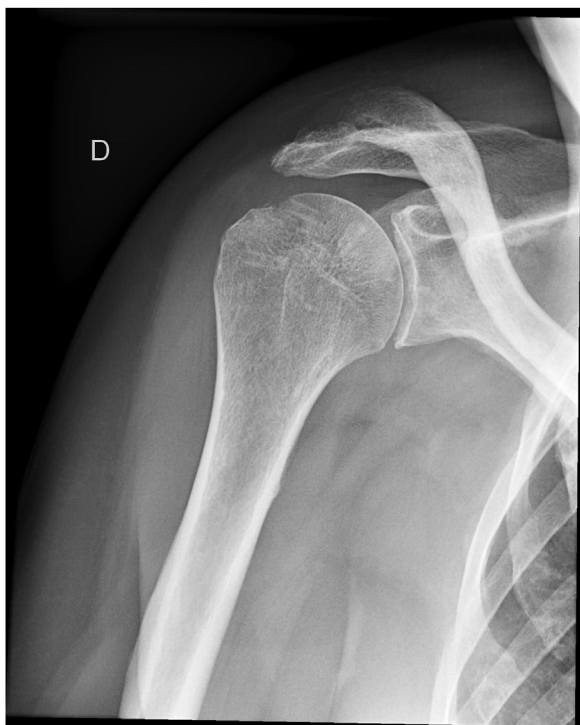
X-ray (AP) follow-up at 6 weeks post arthroscopic rotator cuff repair.
